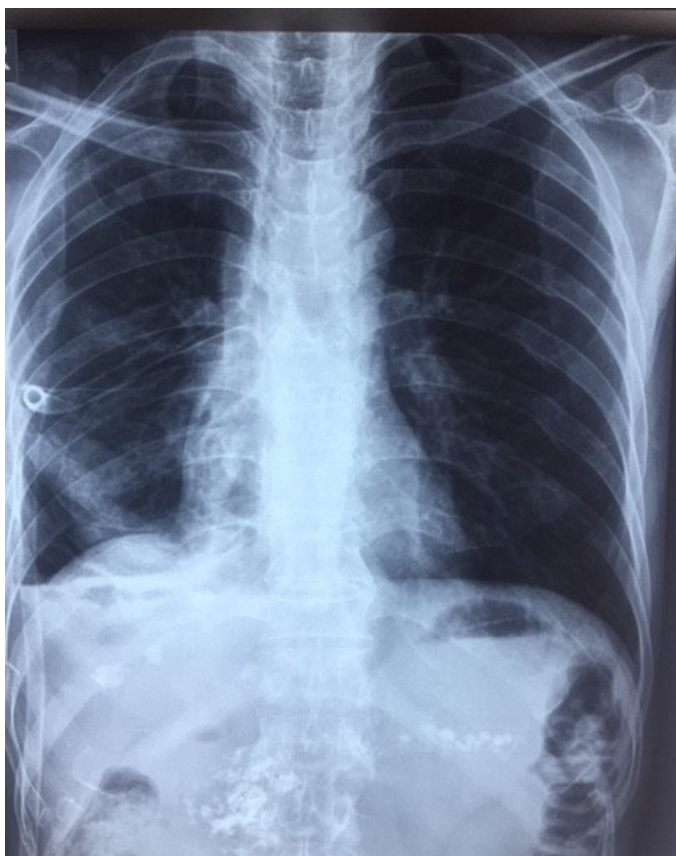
chest x-ray shows expanded lung with ICD in situ and calcification in pancreatic area
